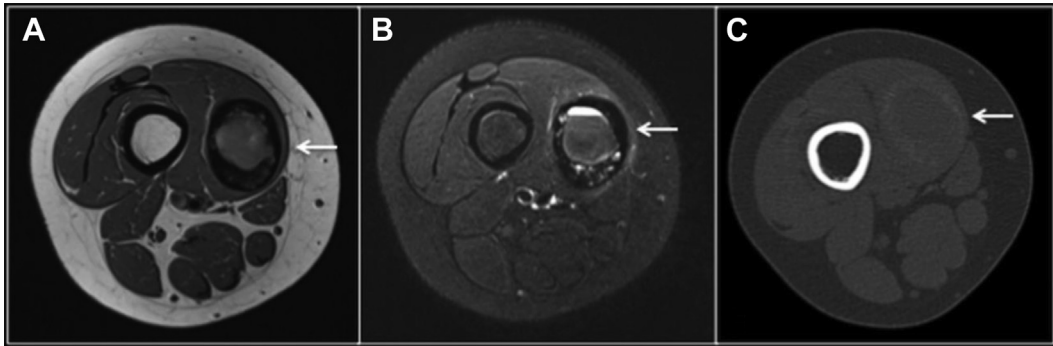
Axial T1 (A), STIR (B), and CT (C) showing myositis ossificans (arrow) in the vastus medialis. (From Saad A, Azzopardi C, Patel A, Davies AM, Botchu R. Myositis ossificans revisited - The largest reported case series. *J Clin Orthop Trauma*. 2021 Mar 13;17:123-127. <https://doi.org/10.1016/j.jcot.2021.03.005>. PMID: 33816108; PMCID: PMC7995649.)
